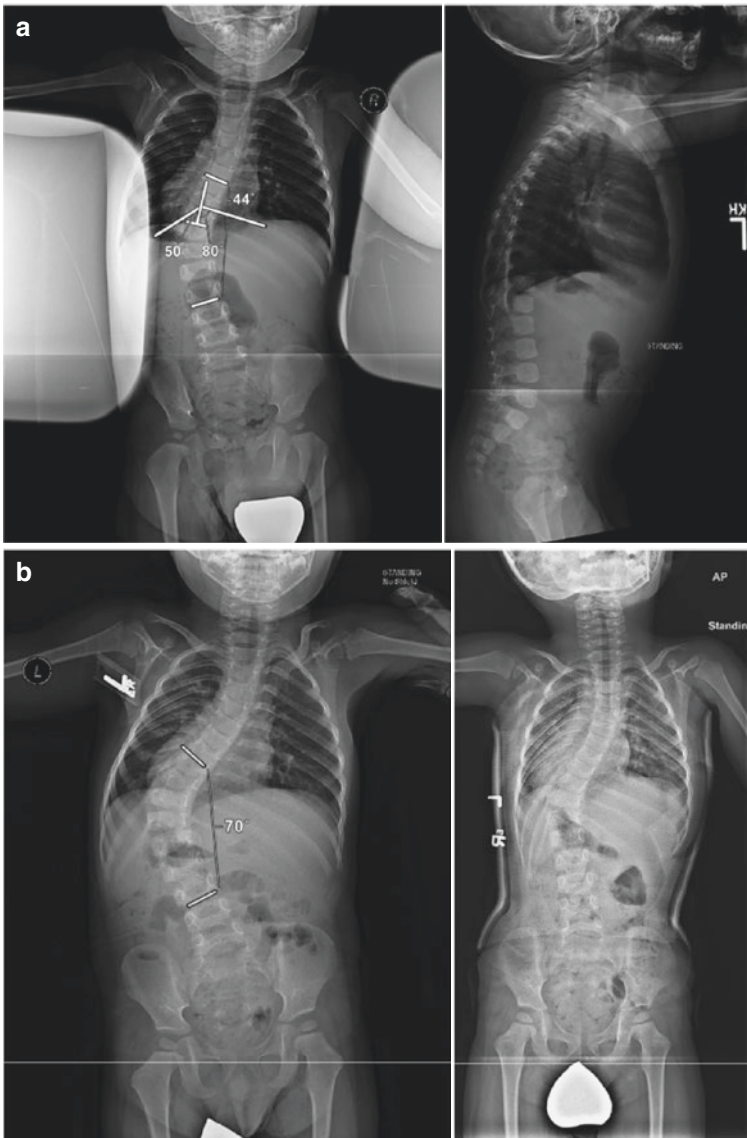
(a) PA and lateral radiographs of an 18-month-old with idiopathic scoliosis. Despite a rib vertebral angle difference of 30° the family elected observation rather than Mehta casting. (b) The curve progressed and Mehta casting was initiated. (c) Casting and bracing were utilized as “delaying tactics” for 2.5 years. At 5 years of age halo gravity traction was initiated. (d) PA and lateral standing radiographs following placement traditional growing rods after 2 months of traction. (e) After four lengthenings the proximal pedicle screw anchors have migrated posteriorly. (f) The proximal anchors were revised in the traditional growing rods exchanged for magnetically controlled rods. The patient is 8 years of age. (g) Between the ages of 8 and 14 the patient underwent 14 Magic lengthenings. Note the extension of the rods and the posterior migration of the proximal anchors and the development of a proximal junctional kyphosis. (h) The magnetically controlled rods were removed and the patient underwent definitive fusion at 14 years of age. Note the correction of the sagittal plane deformities with correction of the proximal junctional kyphosis, restoration of thoracic kyphosis and lumbar lordosis
